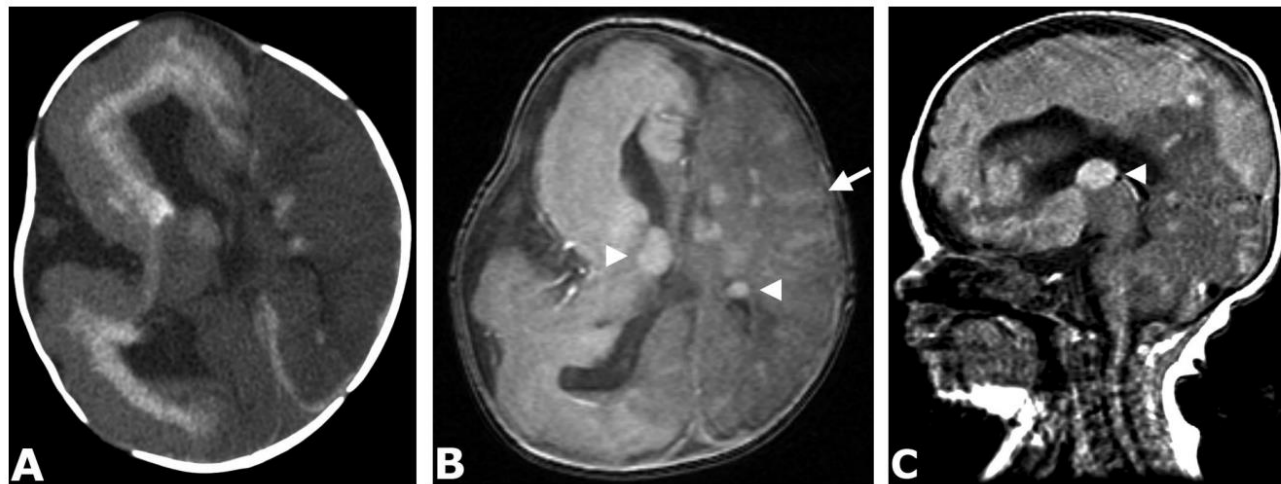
CT without contrast (A) shows hemimegalencephaly and calcified heterotopia outlining the right lateral ventricle. Axial T1-weighted MRI with contrast (B) and sagittal T1-weighted MRI without contrast (C) demonstrate cortical dysplasia in the left hemisphere (arrow) and subependymal nodules (arrowheads).
